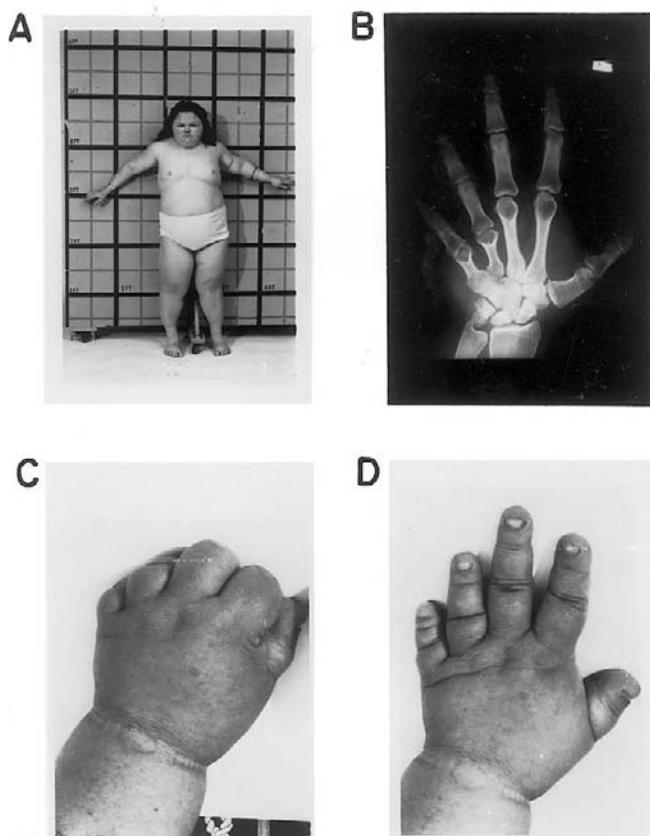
Typical features of Albright hereditary osteodystrophy. (A) A young woman with characteristic features of AHO; note the short stature, disproportionate shortening of the limbs, obesity, and round face. (B) Radiograph of patient's hand showing marked shortening of fourth and fifth metacarpals. (C) Archibald sign, with dimples in place of knuckles. (D) Brachydactyly of the hand, note thumb sign and shortening of the fourth and fifth digits.
